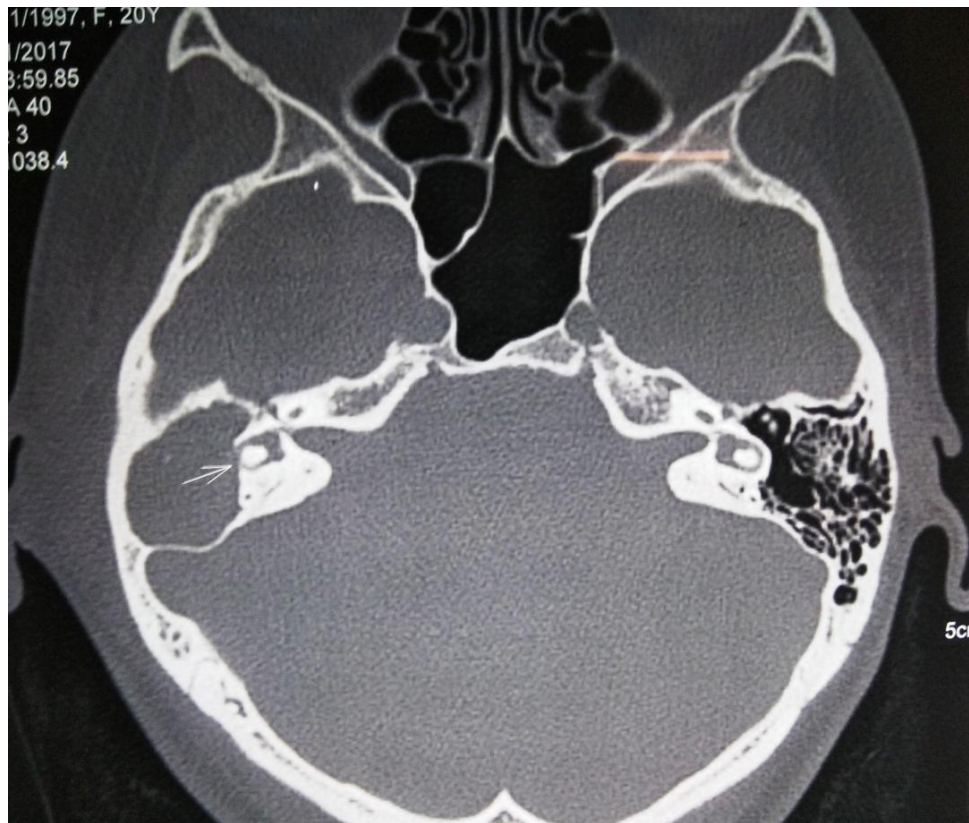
HRCT showing impending LSCC fistula
